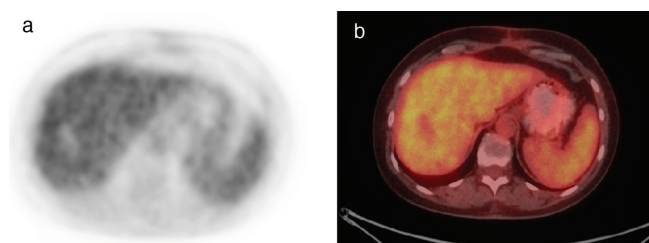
An ^{18}F -FDG-PET/CT of a patient with complete response to the treatment of a liver metastasis of breast cancer 2 months post RFA. The photopenic zone in the 4b liver segment on the metabolic images corresponds with coagulation necrosis. a) PET post-treatment image, axial slice on the level of the 4b segment of the liver, b) fused axial slice on the level of the 4b segment of the liver, post-treatment image
